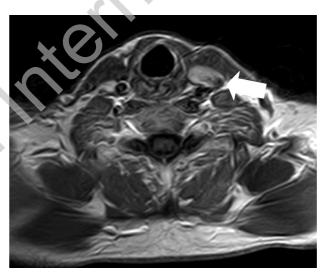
MRI. After contrast enhancement, homogeneous impregnation of the formation.
